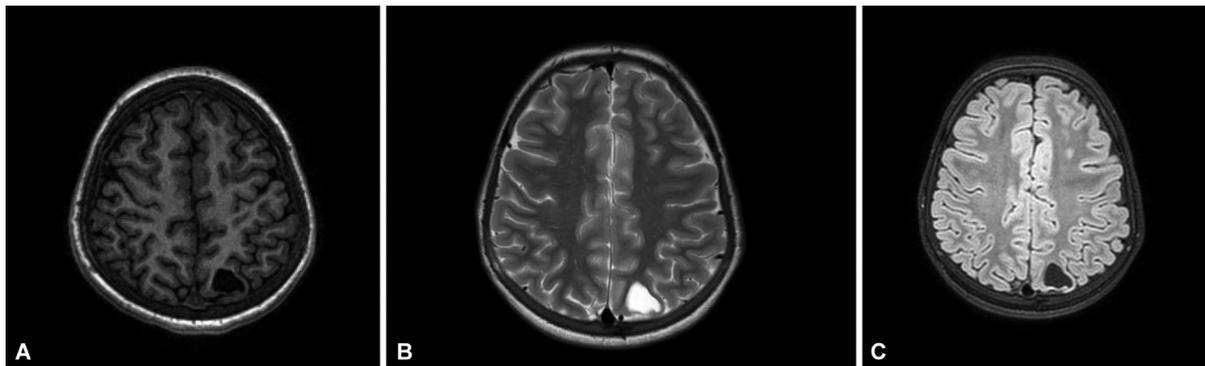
MRI brain axial T1 sequence (A) demonstrating a cystic hypo-intense lesion. T2 sequence (B) demonstrating hyper-intense appearance of the DNET and FLAIR suppression (C). DNET, dysembryoplastic neuroepithelial tumor; FLAIR, fluid-attenuated inversion recovery; MRI, magnetic resonance imaging.
